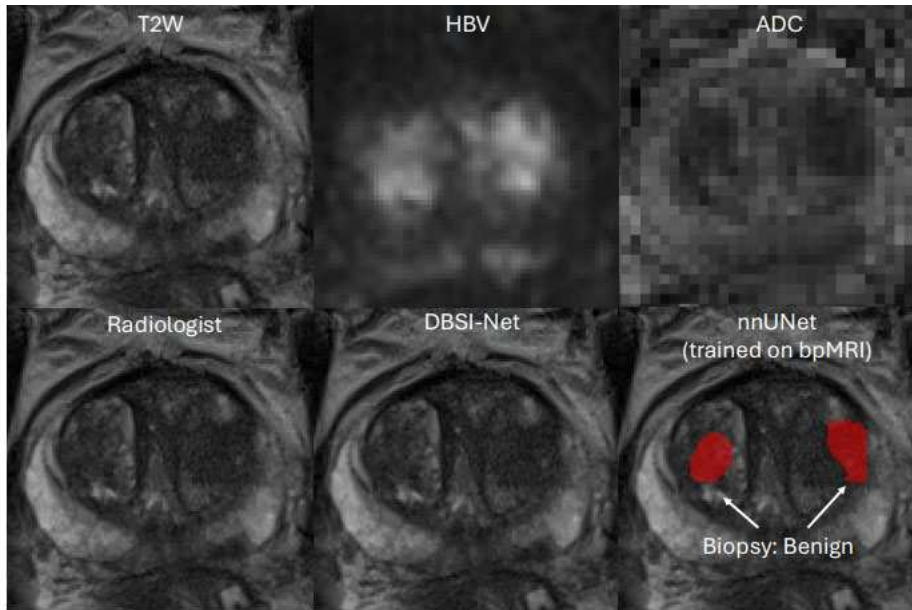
Output of DBSI-Net and nnUNet as a visual overlay to the biparametric MRI (bpMRI) T2-weighted image (T2W) with corresponding high-b value (B2000) (HBV) and apparent diffusion coefficient (ADC) map. nnUNet, trained on bpMRI alone, detected two false positive lesions in areas of benign prostatic hyperplasia that were correctly omitted by DBSI-Net and the radiologist. Images are from a 61-year-old patient with PSA 5.8. Biopsy was benign.
